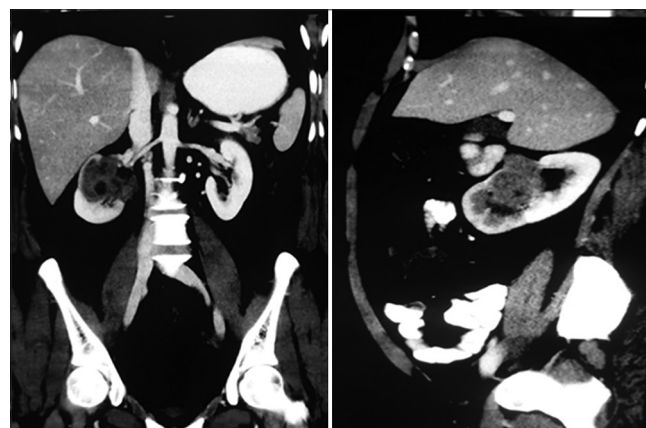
CT scan showing TCC of Right renal pelvis
